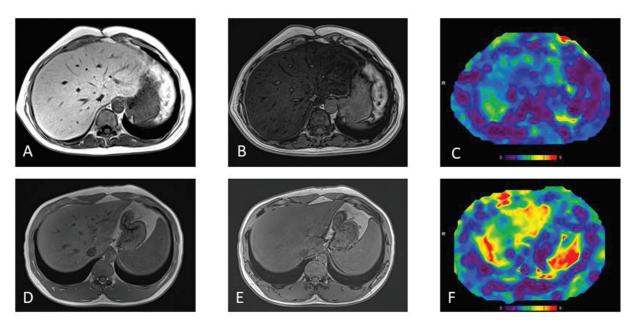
Metabolic dysfunction-associated fatty liver disease (MAFLD) versus metabolic dysfunction-associated steatohepatitis (MASH). (A, B) In-phase (A) and opposed (B) phase T1-weighted images of a 43-year-old man shows severe fat deposition in liver (\sim 50%). (C) Stiffness map shows normal liver stiffness of 2.6 kPa. These findings are suggestive of MAFLD. (D, E), In-phase (D) and opposed (E) phase T1-weighted images in a 32-year-old man shows mild fat deposition (12%). (F) However, stiffness map shows high liver stiffness measurement (5.1 kPa) suggesting advanced fibrosis indicating advanced MASH.
